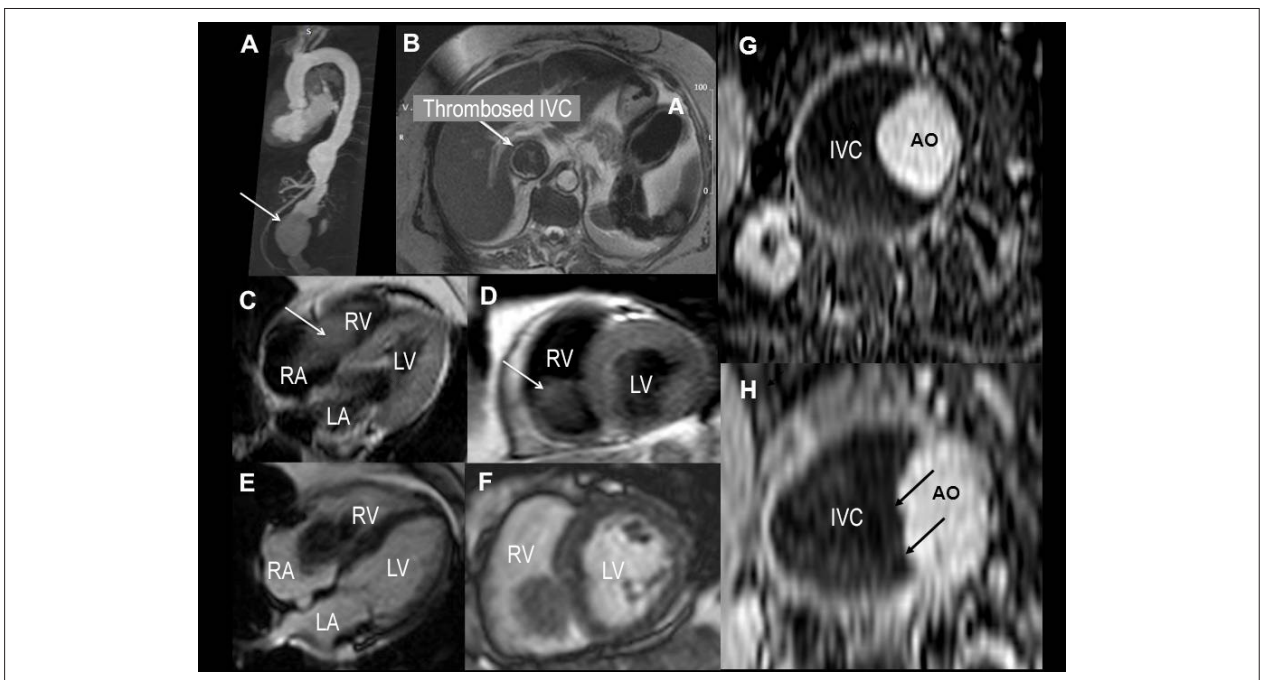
Cardiac Magnetic Resonance Images. (A) Sagittal view of thoracic and abdominal magnetic resonance showing the abdominal aortic aneurysm (arrow), (B) extensive thrombosis of the IVC on a transverse view (arrow) of a SSFP image (Steady State Free Precession) (T2 weighted). Double IR (inversion recovery) – FSE (Fast Spin Echo) in Four-Chamber (C) and Short axis (D) views showing a large thrombus in the right cardiac chambers. LGE (Late gadolinium enhancement) images in Four-Chamber (E) and short axis (F) views showing the large thrombus. Axial Images superior (G) and inferior (H) of abdominal magnetic resonance of a SSFP image. Double IR – FSE. On H, the arrows show the irregular and probably eroded aortic aneurysm into the IVC. IVC: Inferior vena cava; AO: Aorta; LA: Left atrium; LV: Left ventricle; RA: Right atrium; RV: Right ventricle.
